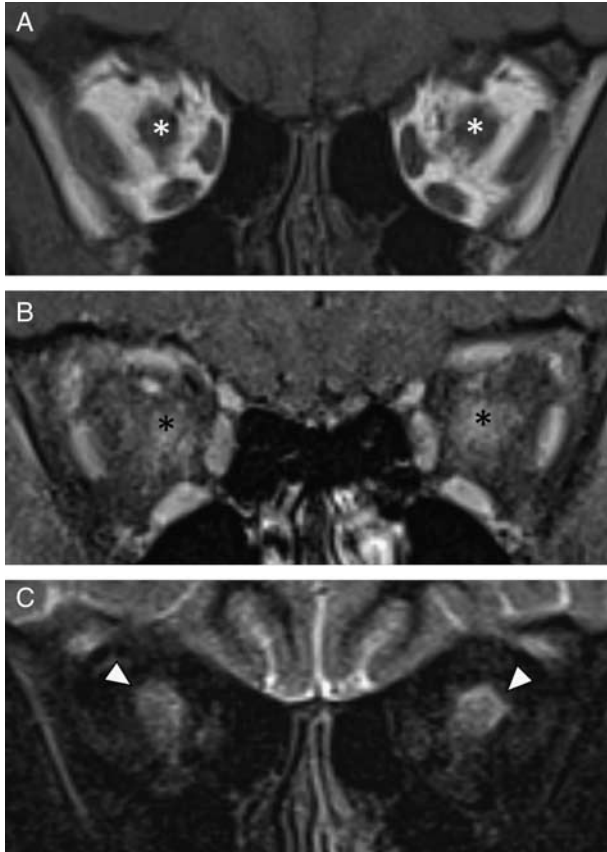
49-year-old woman presented with acute onset of bilateral ocular pain and visual disturbances. Laboratory tests were positive for aquaporin-4 autoantibody, consistent with neuromyelitis optica. Axial (A) T1-weighted precontrast MRI shows enlargement of the bilateral optic nerves (white asterisks). Coronal (B) T1-weighted postcontrast fat-saturated MRI demonstrates abnormal enhancement within the bilateral optic nerves (black asterisks). Coronal (C) T2-weighted MRI shows abnormal T2 hyperintense signal in the bilateral optic nerves (white arrow heads). MRI indicates magnetic resonance imaging.
